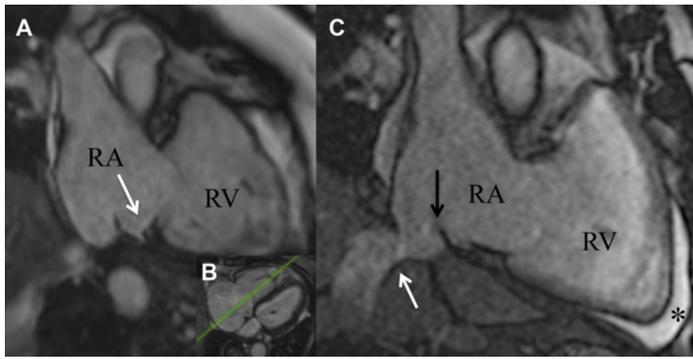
Isthmus pouches that are frequently present, a prominent Eustachian ridge and large pectinate muscles may impede catheter stability and navigation to target sites leading to poor tissue contact and low radio frequency energy delivery. A and B: Septal pouch (white arrow) of the cavotricuspid isthmus in a balanced steady-state free precision sequence image [as visualized in the transversal plane (B)]; C: Kinking of the vena cava inferior junction in the right atrium (white arrow) and a eustachian valve (black arrow) was found. Anterior to the right ventricular apex, a pre-existing pericardial effusion was located (asterisk). Citation: Ulbrich S, Huo Y, Tomala J, Wagner M, Richter U, Pu L, Mayer J, Zedda A, Krafft AJ, Lindborg K, Piorowski C, Gaspar T. Magnetic resonance imaging-guided conventional catheter ablation of isthmus-dependent atrial flutter using active catheter imaging. *Heart Rhythm O2* 2022; 3: 553-559 [PMID: 36340492 DOI: 10.1016/j.hroo.2022.06.011]. Copyright © 2022 Heart Rhythm Society. Published by Elsevier Inc. (Reproduced under the terms of the Creative Commons CC-BY license)[40].
